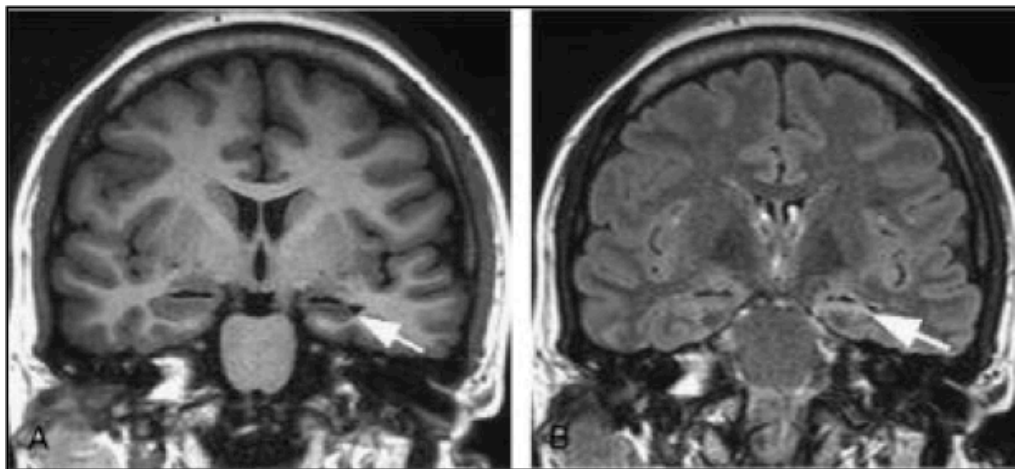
Coronal MR images showing (A) atrophy of left hippocampus on T1-W (arrow), and (B) atrophy and increased signal in left hippocampus (arrow) on FLAIR sequence.
